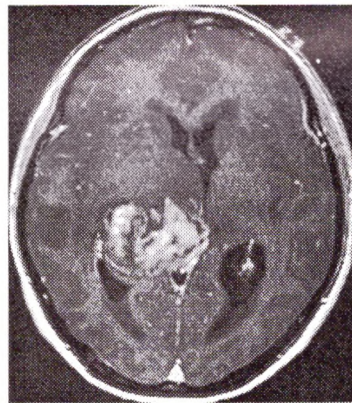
Magnetic resonance images of a 33-year old female with a malignant tumor in the right thalamus and a hydrocephalus. Tumor biopsy and restoration of the CSF flow were the aims of the endoscopic procedure. Because of a partly obstructed right foramen of Monro, left-sided ETV was performed and the tumor was approached transseptally. Neuronavigation was essential for transseptal biopsy.
